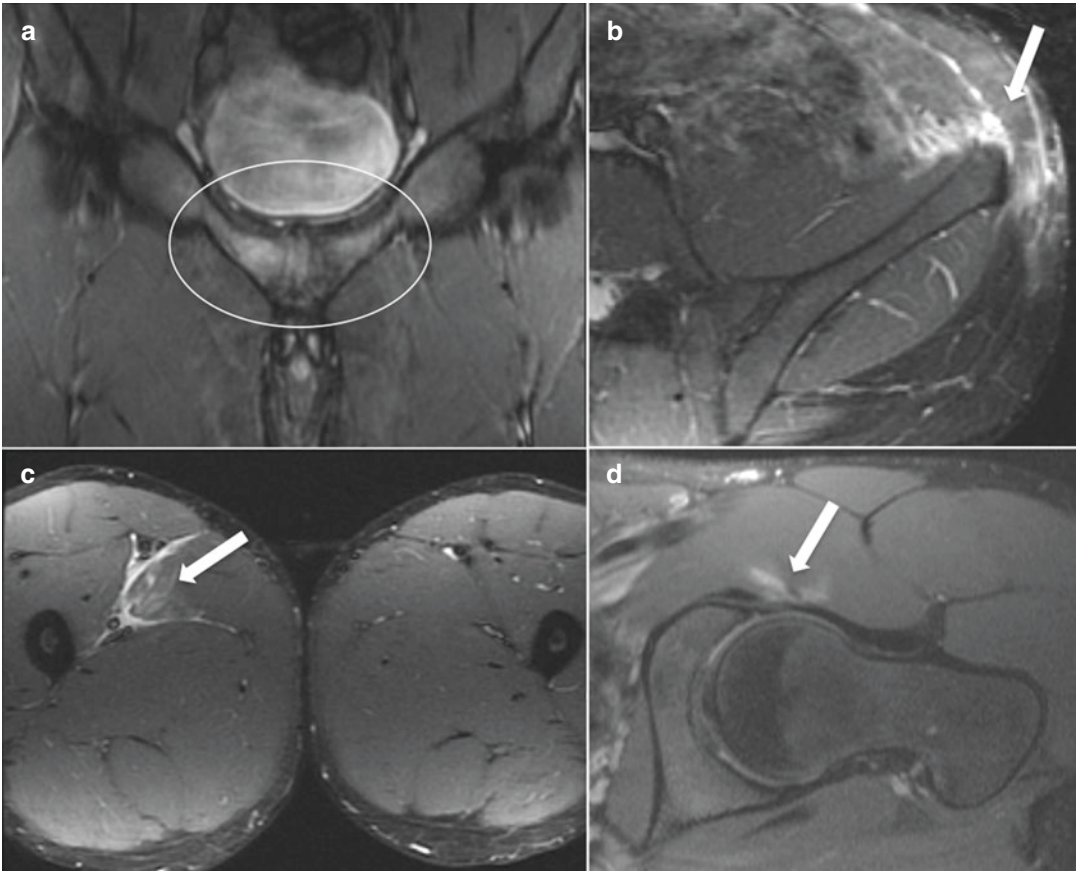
FAI-associated injuries and differential diagnoses. (a) Oblique-coronal inversion-recovery MRI demonstrating edema and subchondral sclerosis at the pubic symphysis (circle), consistent with osteitis pubis. (b) Axial inversion-recovery MRI of the abdomen demonstrating extensive edema within the left flank
